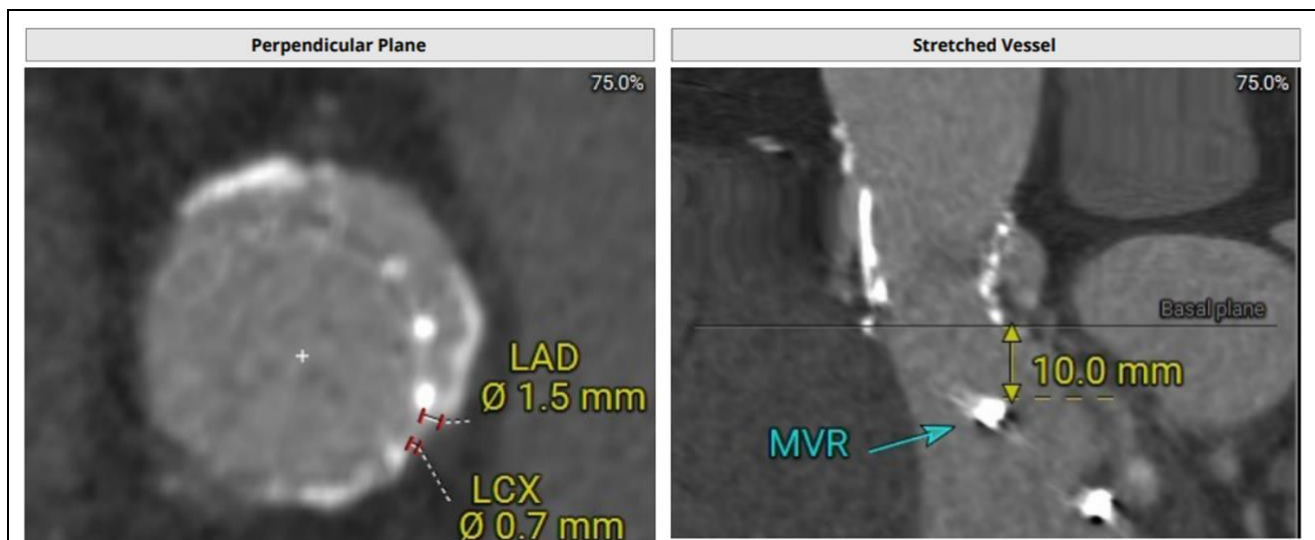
CT-derived anatomical assessment demonstrating the layered prosthetic anatomy.
